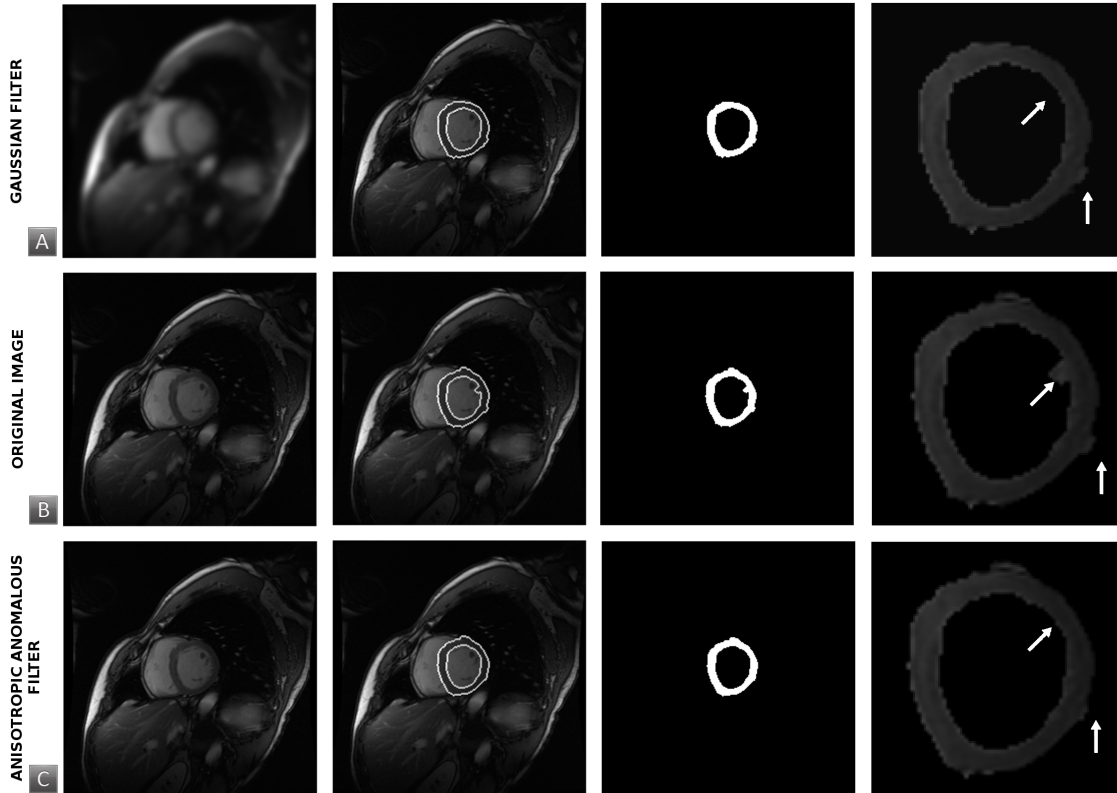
Myocardial segmentation in the short axis of an MRI image with the AAD filter, Gaussian filter and the original image. All the results are shown in a row, where it has the same order: filtered image, myocardial segmentation, area segmented and a myocardial segmented amplification, respectively. A) Gaussian filtering, B) Original image without any filtering application, and C) Anisotropic anomalous diffusion filtering. See the white arrows that are pointing to a better local region segmentation.
